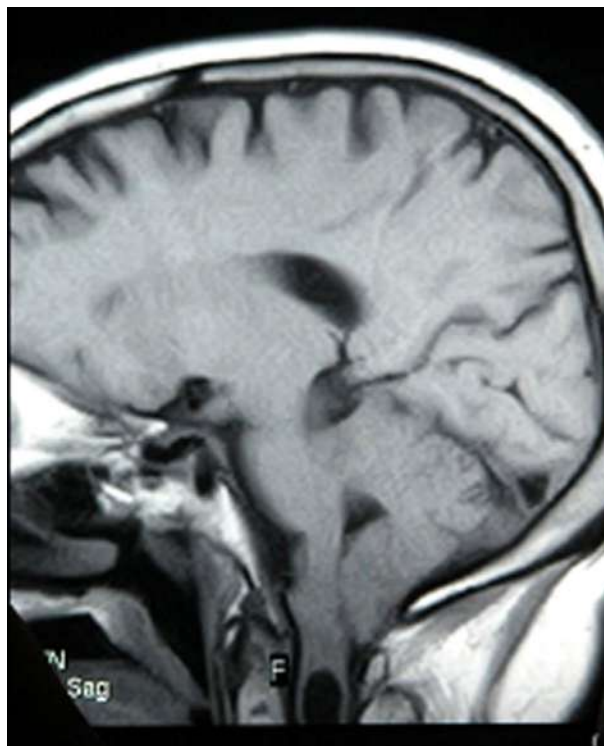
CMI with syrinx in the cervical spinal cord (sagittal view, T1 weighted MRI of the cervical spine).
